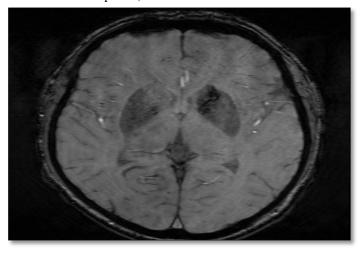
MRI of the brain (SWI).
